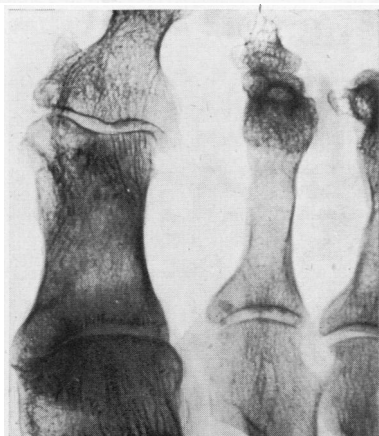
Case 3. Radiograph of big toe: note "cyst" formation and similarity to changes in Case 1.
